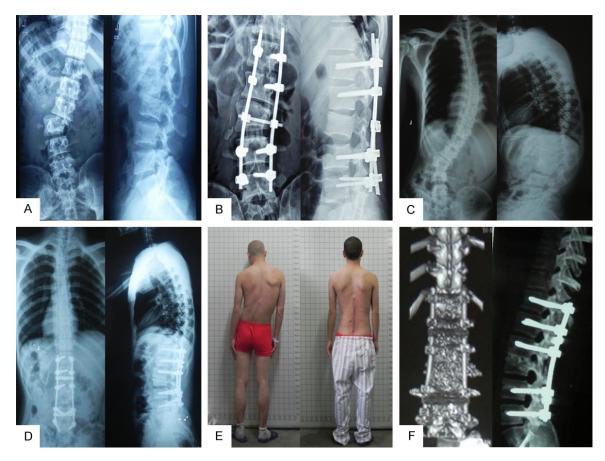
A 35-year-old male with L3 fracture and L2 dislocation underwent a posterior approach surgery in a local hospital. The patient's muscle strength recovered from grade 2 to grade 4 1 year after the operation. A. Preoperative X-ray showed L3 fracture and L2 dislocation; B. X-ray of the lumbar spine 1 year after surgery; C. Scoliosis deformity occurred 6 months after removal of the internal fixation; D. Posterior osteotomy, iliac bone grafting, and internal fixation, and the scoliosis was completely corrected; E. Trunk appearance before and after surgery; F. CT scan of lumbar spine 1 year after surgery.
